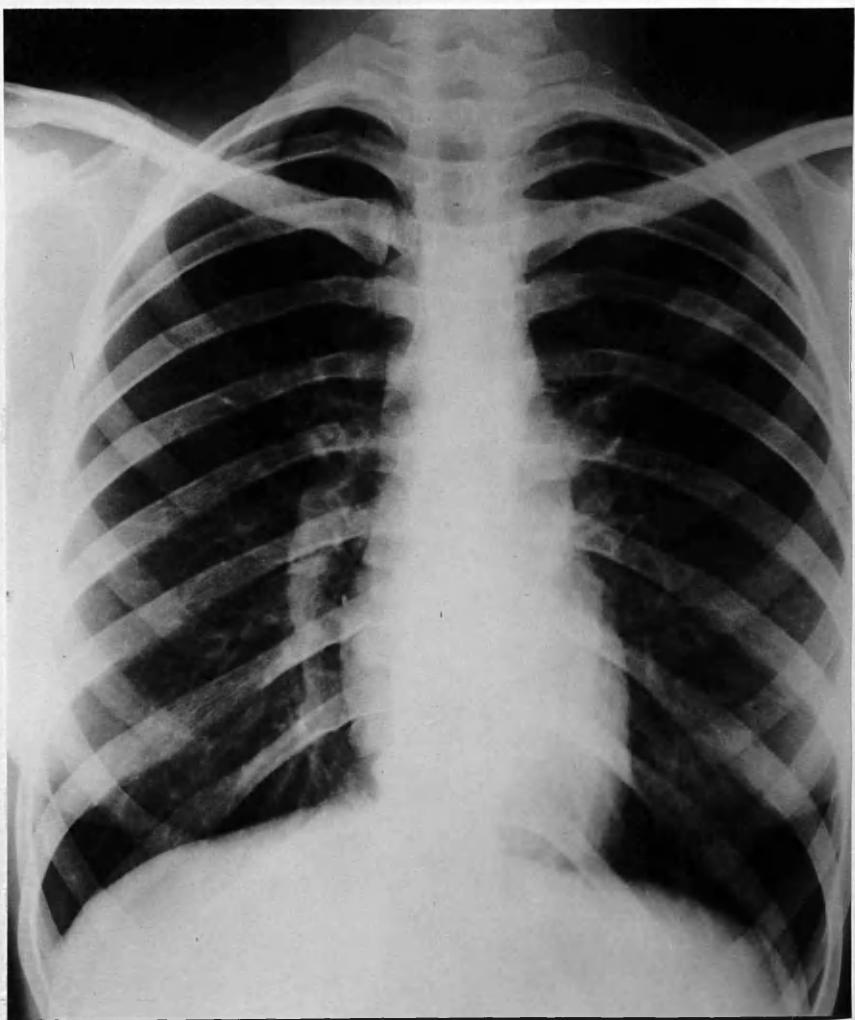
Radiograph of chest taken 21.10.52. A typical
